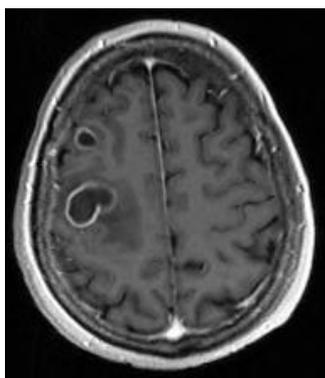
MRI (Post contrast) showing two right frontal lobe rim enhancing lesions at presentation
